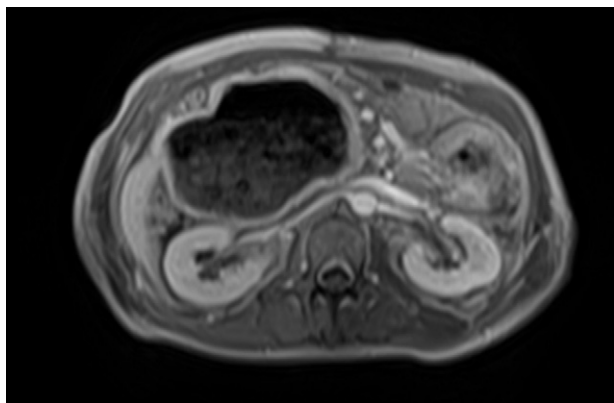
MRI of the abdomen with the cyst in the R upper quadrant.
